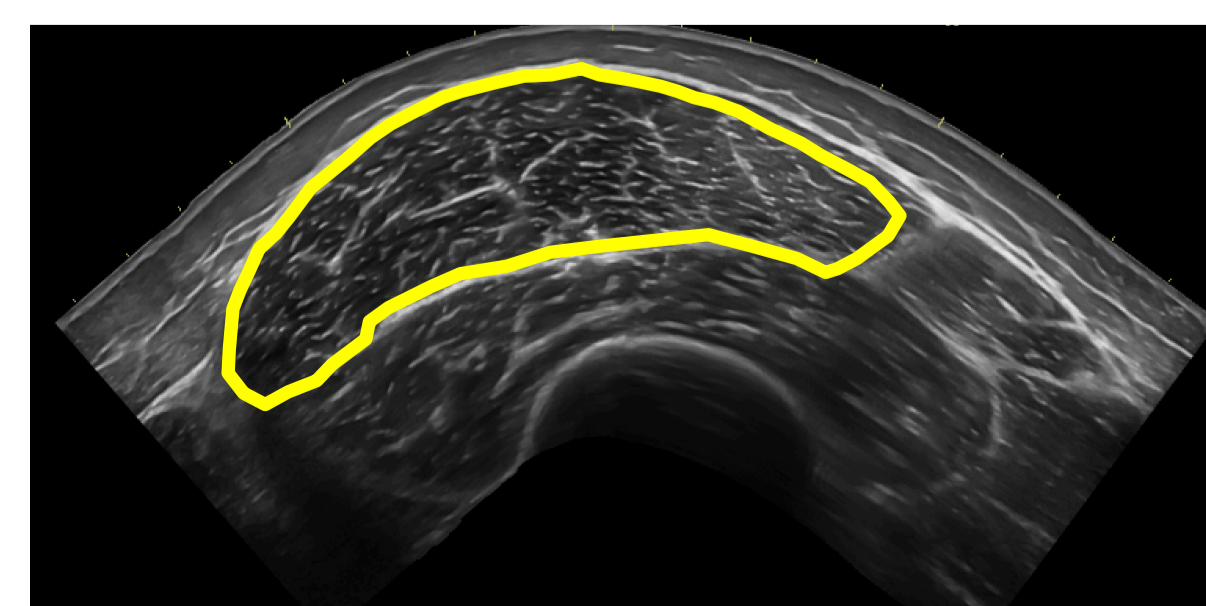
Example ultrasound image of the VL
